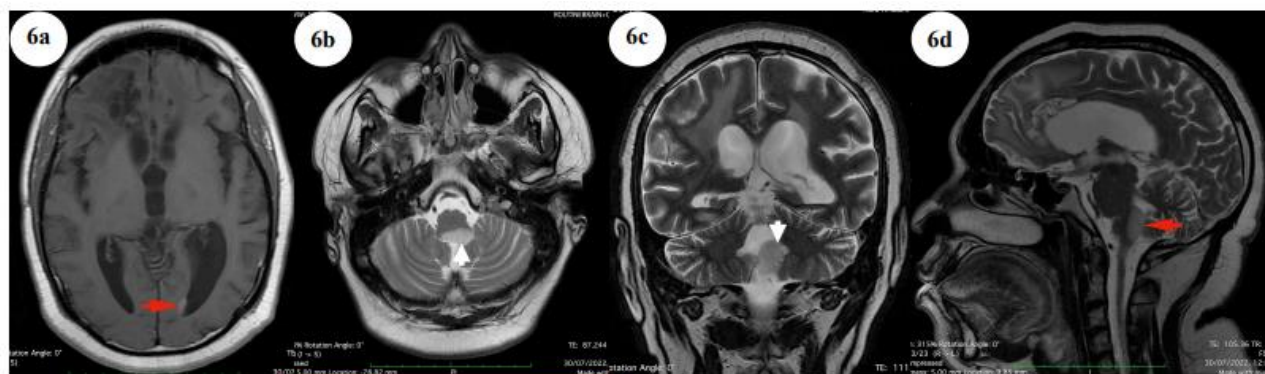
(a-d): Brain Magnetic Resonance Imaging (18 months post-initial diagnosis).
